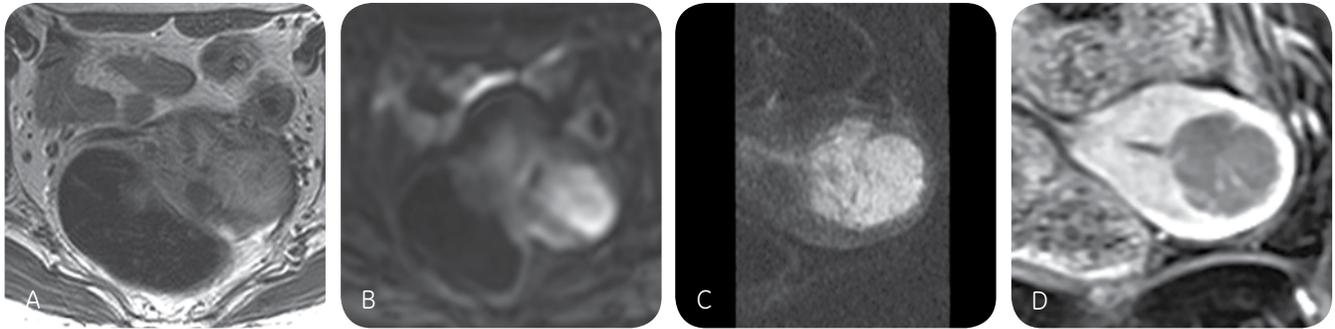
T2w (A) and conventional DWI (B) show a uterine corpus tumor, and the tumor/myometrial interface is indistinct. Oblique-axial (short axis of the uterus) FOCUS DWI (C) increases the conspicuity of the tumor-myometrial interface, and the residual myometrium is clearly demonstrated compatible with oblique-axial 3D CE-T1w with fat suppression (D).
